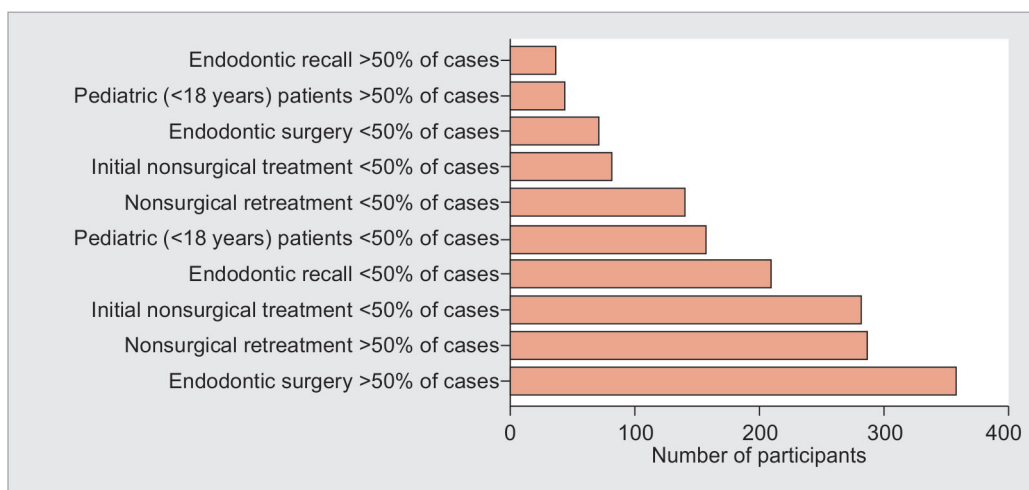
Consideration of uses of CBCT
